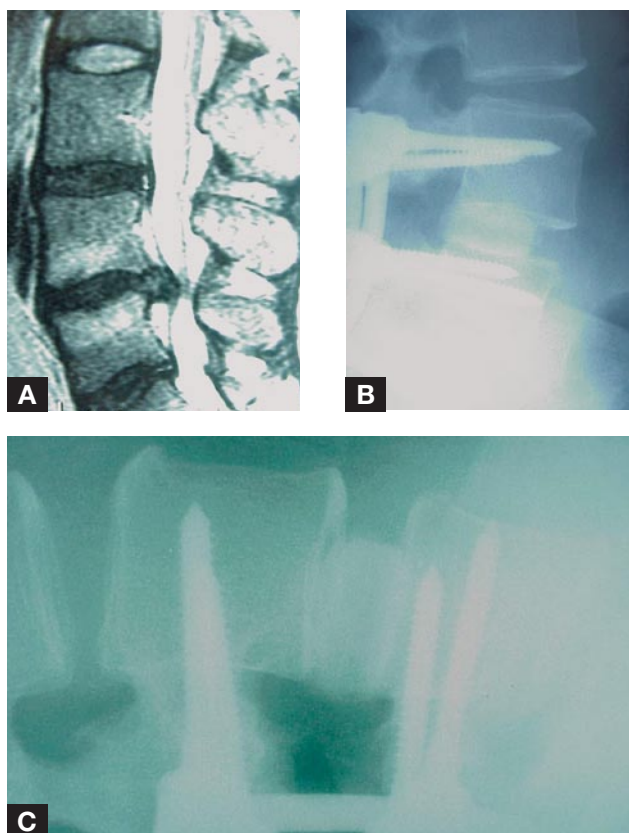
(A) A woman in her late 40s with 9-month history of back pain refractory to nonsurgical treatment. Magnetic resonance imaging shows herniated, degenerative L4-L5 disc with Modic changes in vertebral bodies. Discogram confirmed L4-L5 disc was only source of pain. (B) Patient underwent L4-L5 posterior lumbar interbody fusion. Back pain resolved. Lateral radiograph at 12 months shows solid interbody fusion. (C) Lateral radiograph at 24 months shows solid interbody fusion.
